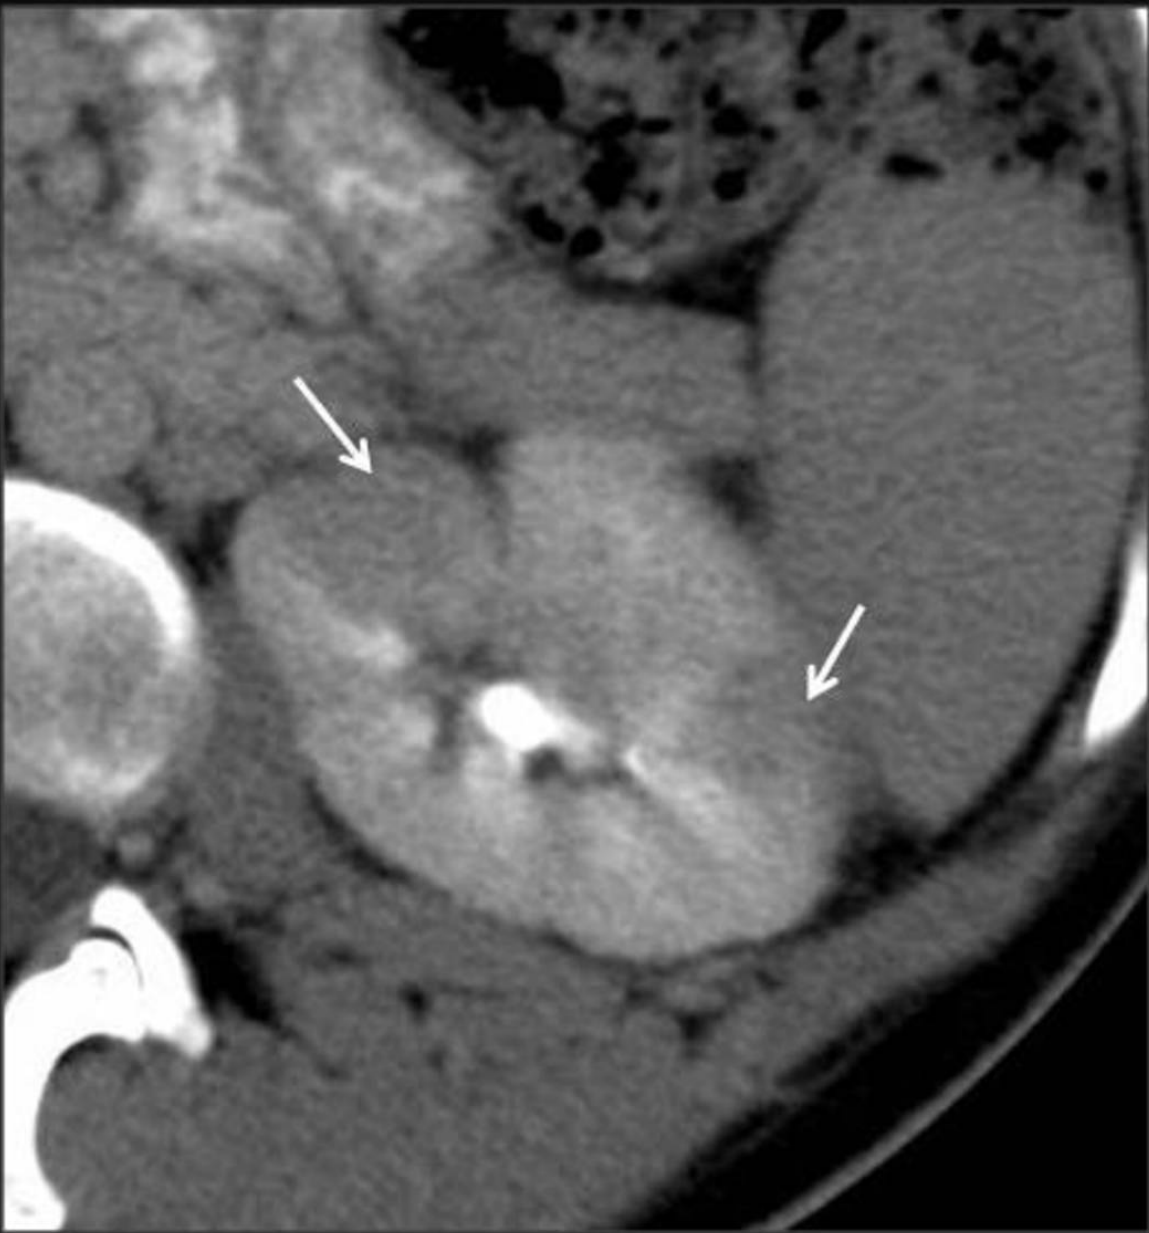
Acute pyelonephritis. Contrast-enhanced axial CT image (excretory phase) shows several wedged-shape areas of decreased enhancement consistent with a striated nephrogram (arrows).
